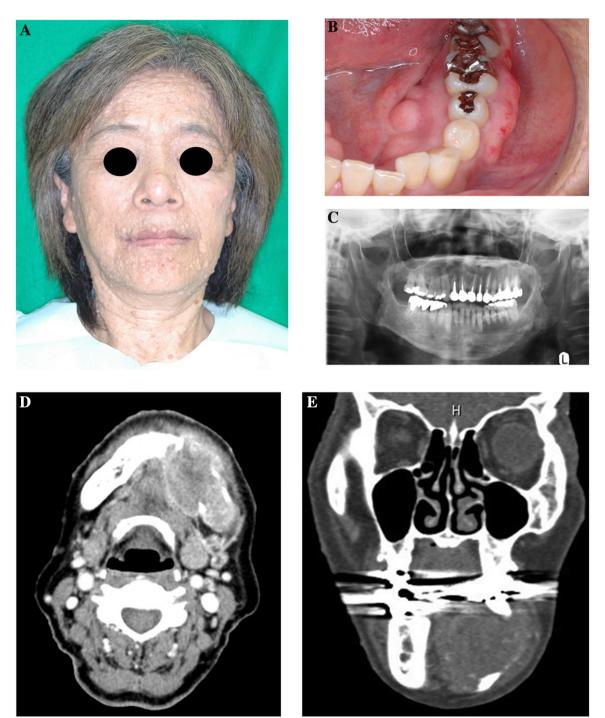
Preliminary findings. (A) The extraoral examination revealed numerous cutaneous neurofibromas that manifested as small bumps on the patient's skin. (B) The intraoral examination revealed diffuse swelling of the left mandible. (C) Panoramic radiography revealed a poorly defined radiolucent lesion in the left mandible. (D, E) Computed tomography revealed a poorly defined homogeneous enhancement of the mass with destruction of the cortical bone in the left mandible.
